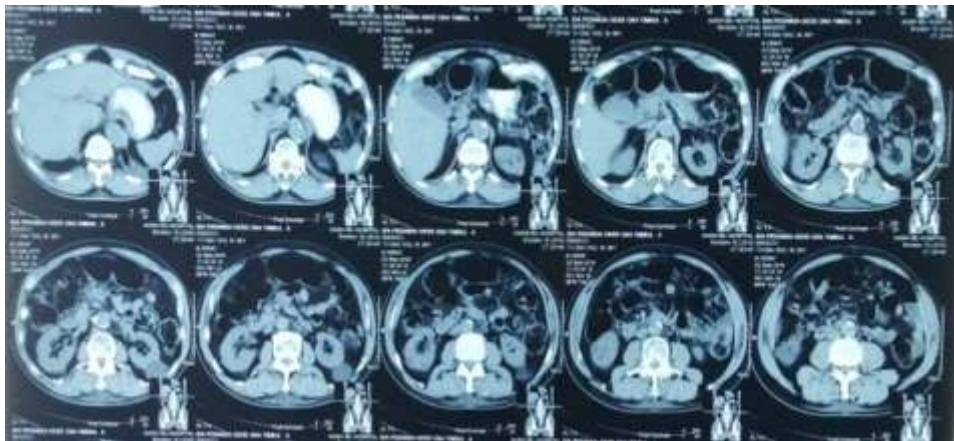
CT scan of the abdomen showed a dilatation of the colon and thickening of the connective tissue around the abdominal organs and mesentery
